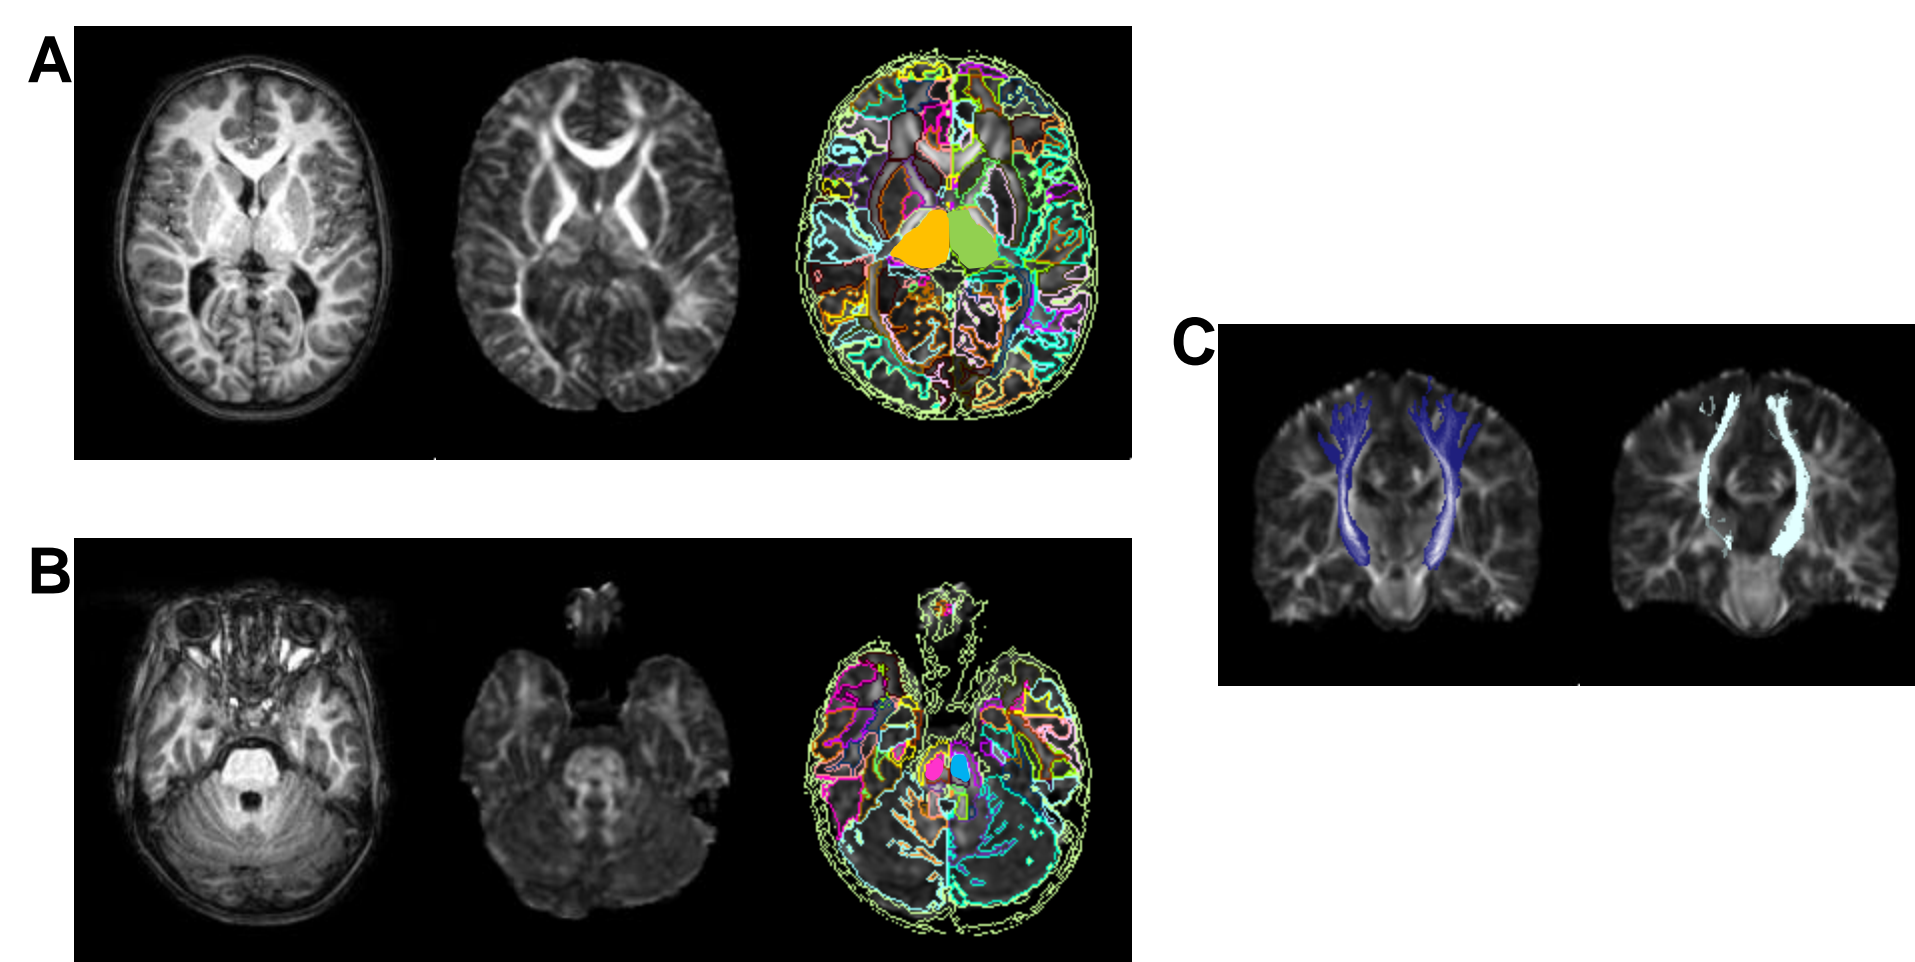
A and B show axial conventional MR images (left), fractional anisotropy (FA) map of diffusion tensor imaging (middle), and parcellated ROI map superimposed on FA map (right). A shows bilateral thalamus (yellow and light green) and B shows bilateral CST at the pons level (pink and light blue). C shows the coronal image of probabilistic tracts, superimposed to the normalized FA images of the same patient. (Left: thalamic radiation to precentral area, Right: thalamic radiation to postcentral area)
